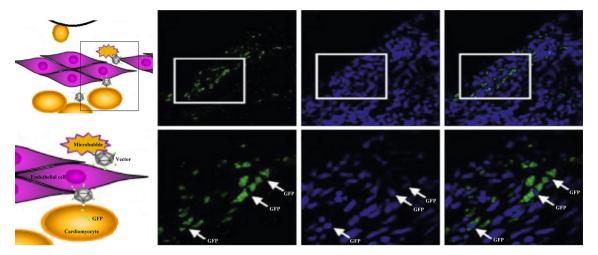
UTMD gene delivery in tissue. The ultrasound application leads to holes in cell membrane and capillary, which facilitates the uptake of therapeutic GFP-mark gene (16). UTMD, ultrasound targeted microbubble destruction.
